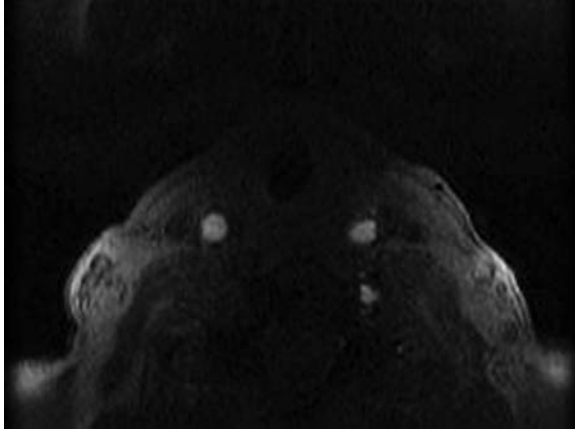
MRI slices reconstruction
